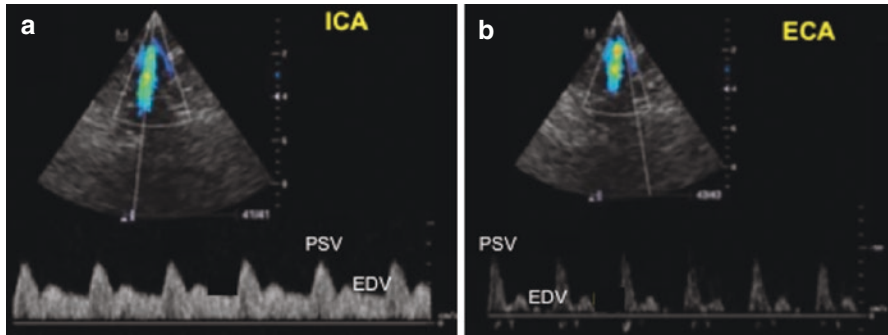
Doppler spectral waveform by TCCS approach through submandibular acoustic window: (a) internal carotid artery (ICA), peak systolic velocity, (PSV) and end-diastolic velocity (EDV) (low resistance); (b) external carotid artery (ECA), peak systolic velocity (PSV), and end-diastolic velocity(EDV) (high resistance)
